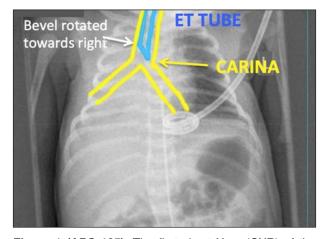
(ABS 125). The first chest Xray (CXR) of the newborn.
